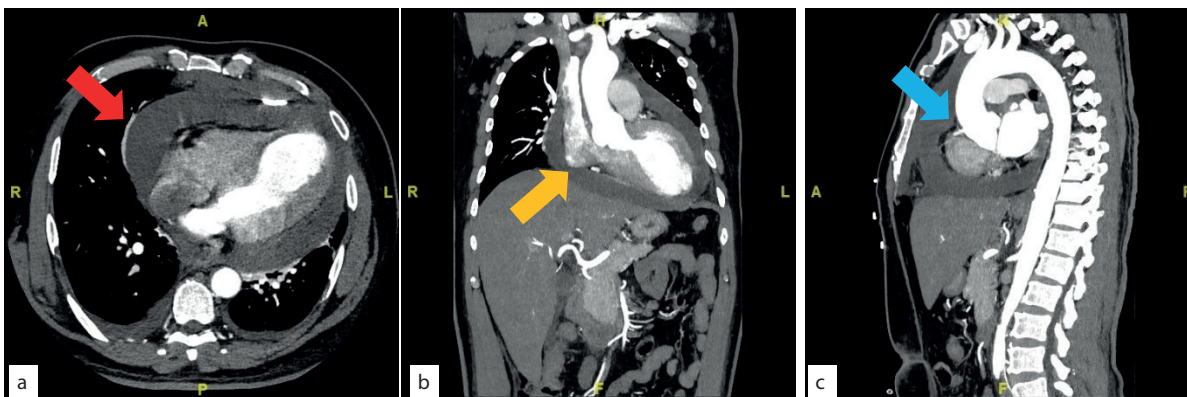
Chest computed tomography angiography (CTA): (a) Axial view, (b) Coronal view, and (c) Sagittal view confirmed the presence of a large pericardial effusion measuring 2.8 cm in maximum thickness (red arrow), along with the collapse of the right ventricle relative to the left ventricle (orange arrow), suggestive of the tamponade effect. There is no evidence of aortic aneurysm or dissection (blue arrow).
